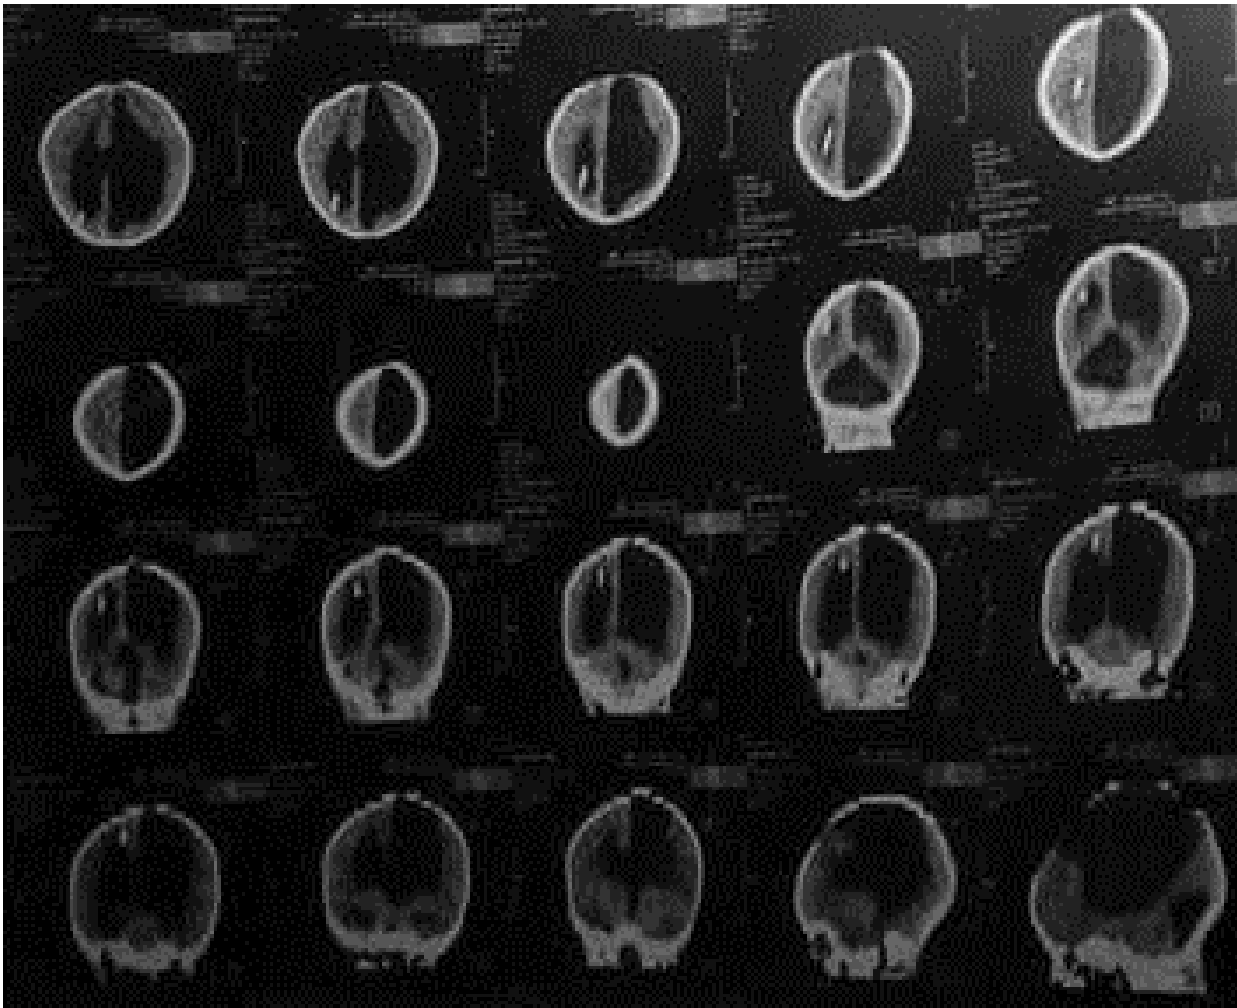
Axial, coronal and sagittal non contrast CT scan after 3 months follow up showed incomplete evacuation of left ventricle.
